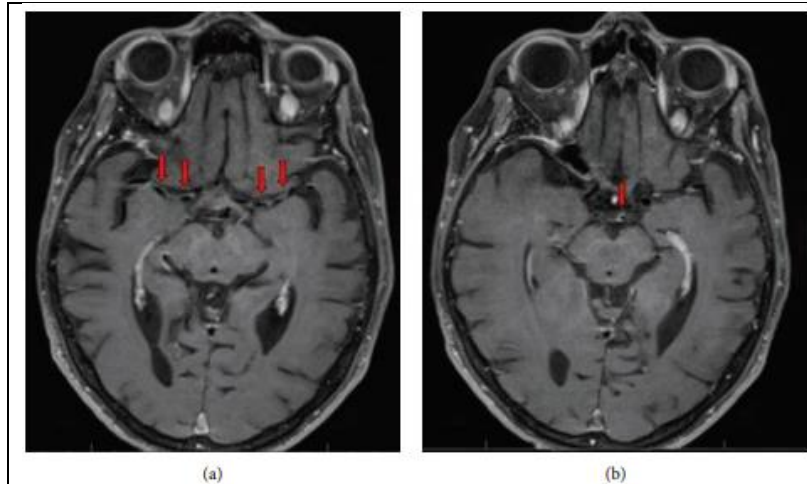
(a) Bilateral MCA vessel walls are enhanced in the MRI brain T1 post-contrast picture. (b) MRI brain T1 post-contrast picture shows enhancement of the basilar artery vessel wall.
